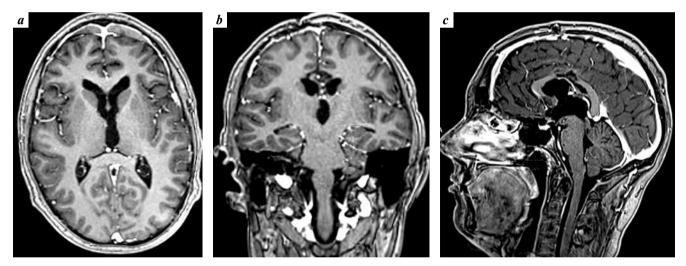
Brain magnetic resonance imaging with contrast enhancement 3 months post operative (T1-weighted imaging): a- axial view; b- coronal view; c- sagittal view. Total resection of the tumor. There are no signs of hydrocephalus, VKR-2 = 16 %
